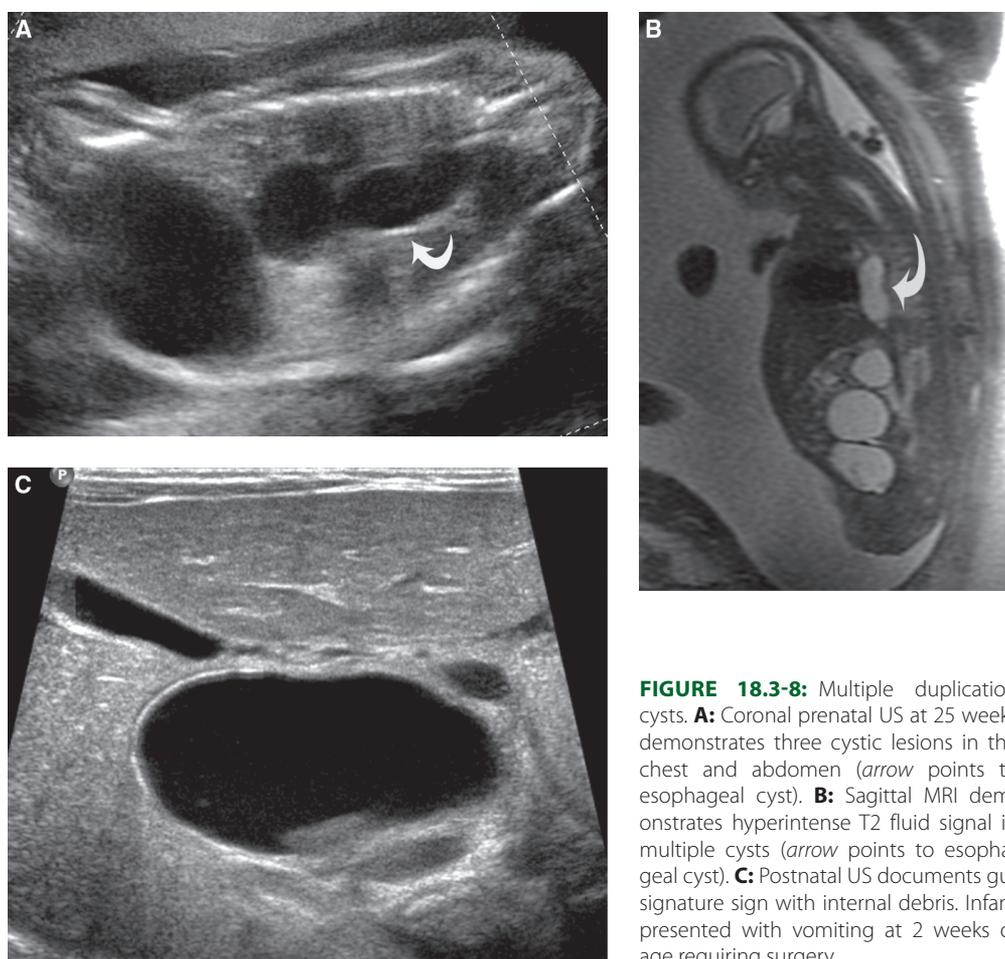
Multiple duplication cysts. A: Coronal prenatal US at 25 weeks demonstrates three cystic lesions in the chest and abdomen (*arrow* points to esophageal cyst). B: Sagittal MRI demonstrates hyperintense T2 fluid signal in multiple cysts (*arrow* points to esophageal cyst). C: Postnatal US documents gut signature sign with internal debris. Infant presented with vomiting at 2 weeks of age requiring surgery.
